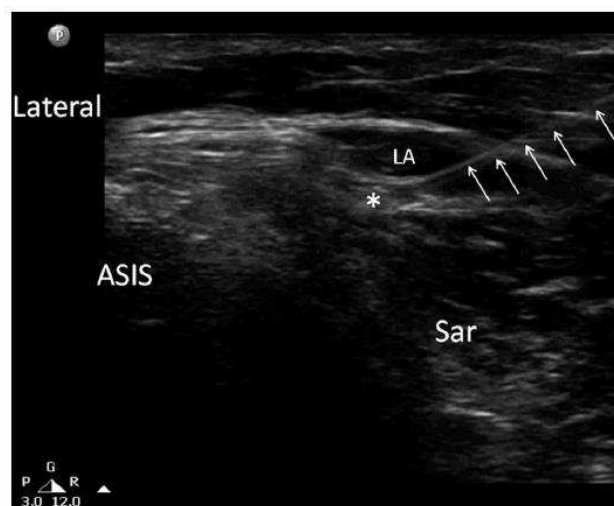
Post injection ultrasonogram; the needle is marked with a line arrow line. LA denotes local anesthesia. *LFCN. (www.usra.ca) [9].
